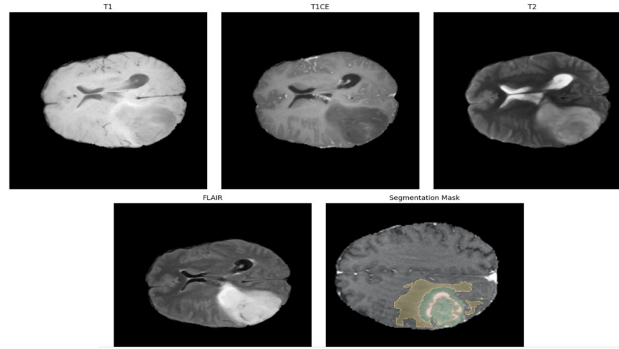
Example of a brain tumor from the BraTS 2020 training dataset. Red: Enhancing Tumor (ET), Green: Non-enhancing Tumor/Necrotic Tumor (NET/NCR), Yellow: Peritumoral Edema (ED). T1-weighted sequence, T1-weighted contrast-enhanced sequence, T2-weighted sequence, FLAIR sequence, and T1-weighted contrast-enhanced sequence with labelmap overlay.
